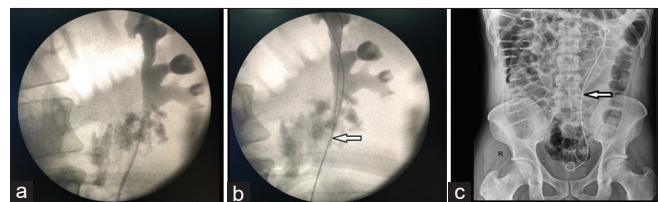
(a) Retrograde pyelography showing partial tear in proximal ureter with contrast extravasation noted and rest of the contrast outlining pelvicalyceal system. (b) Guidewire (arrow) secured in the left ureter and position confirmed under fluoroscopy. (c) Post-operative X-ray kidney, ureter, and bladder region shows double J stent (arrow) in position, which was kept for 3 weeks
